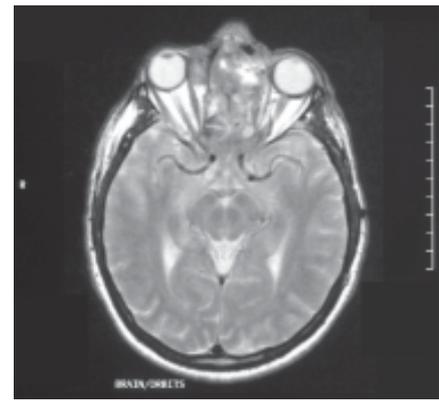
An axial MRI scan taken shortly before the onset of intractable pain showing tumour replacing the ethmoid sinuses.
